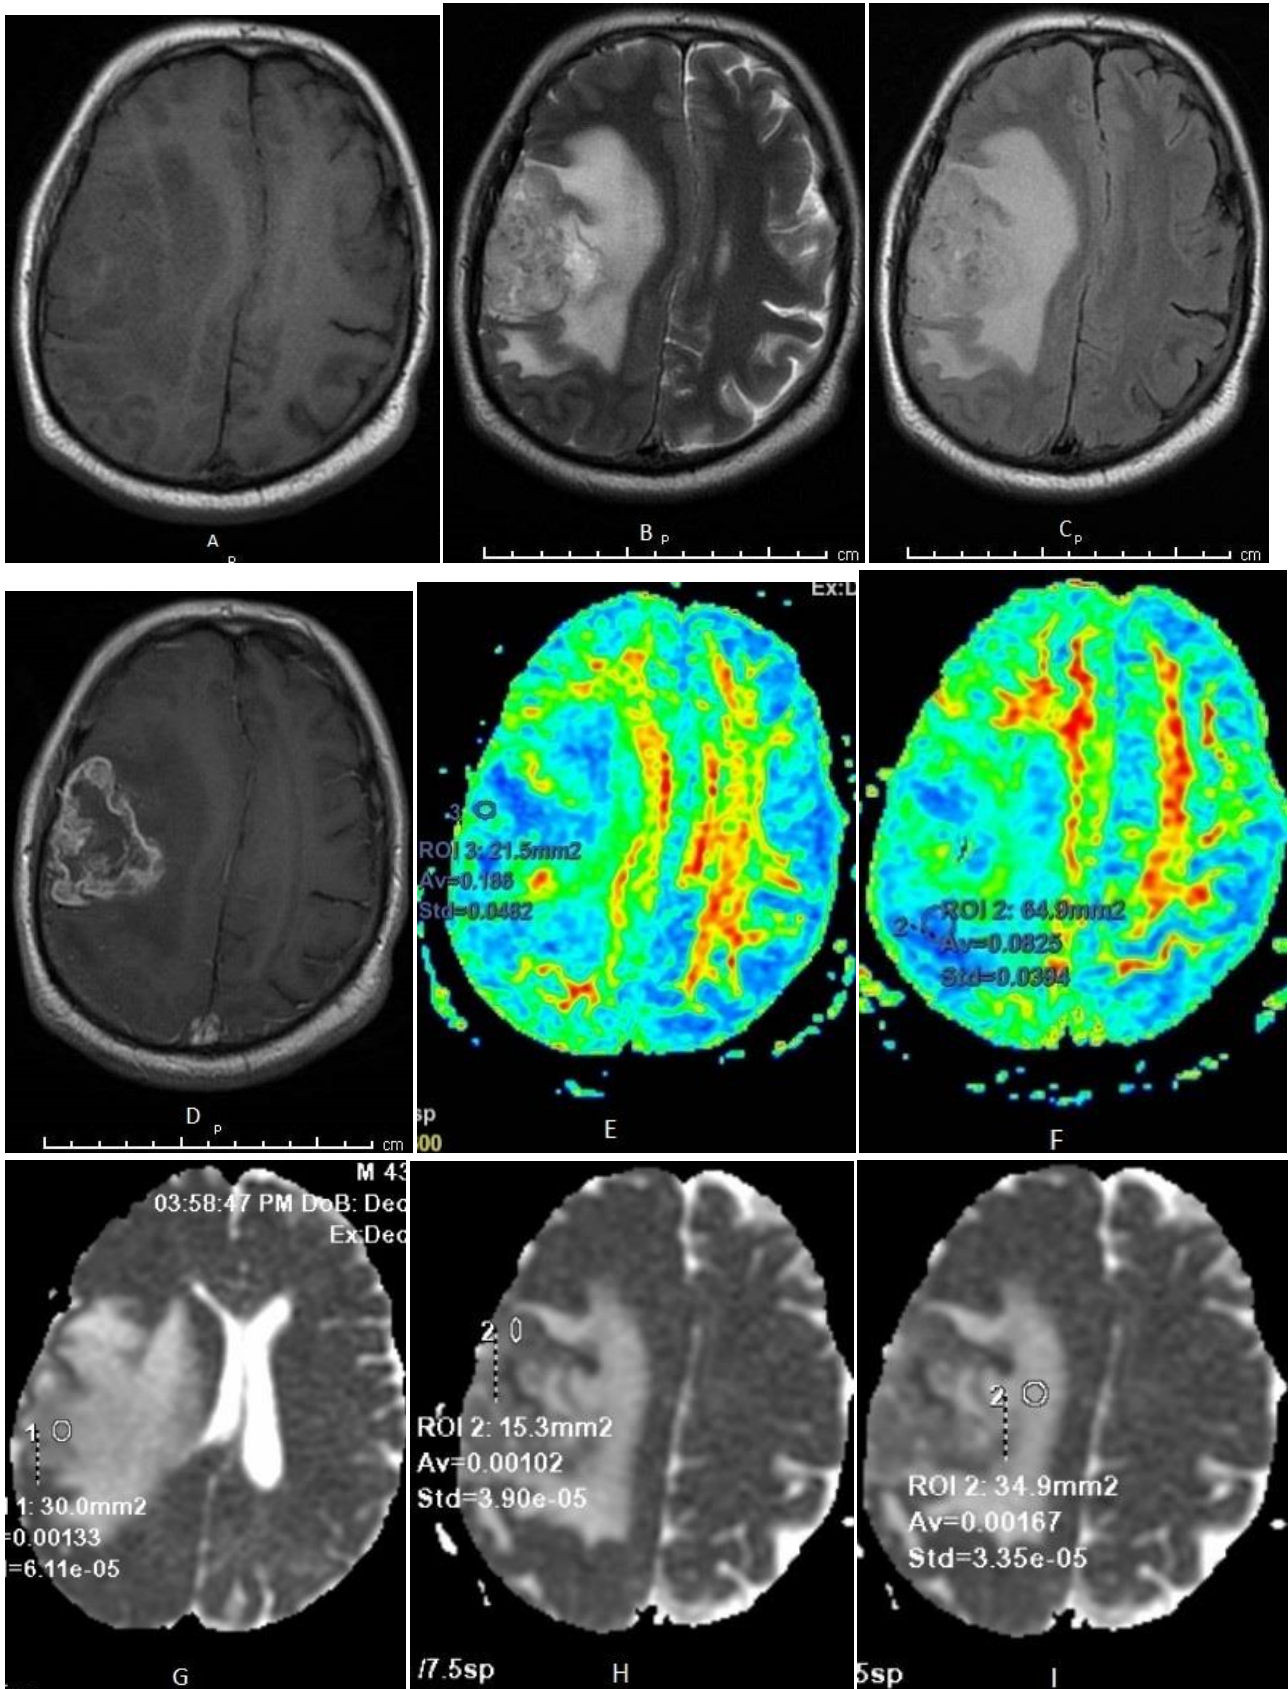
Male patient 43 years old, pathologically proved high grade glioma (A), (B) and (C) images Axial T1, T2 and FLAIR images respectively, showing right fronto-parietal intra axial lesion with surrounding vasogenic edema and heterogeneous post contrast enhancement (D). (E) and (F) FA map with two regions of interest measured within the enhancing part of the tumor and within the immediate peri-tumoral edema demonstrate decreased FA with displacement of fibres, (G) and (H) ADC map with two regions of interest measured within the enhancing part of the tumor and (I) within the immediate peri-tumoral edema demonstrates slightly decreased ADC within the immediate peri-tumoral edema
